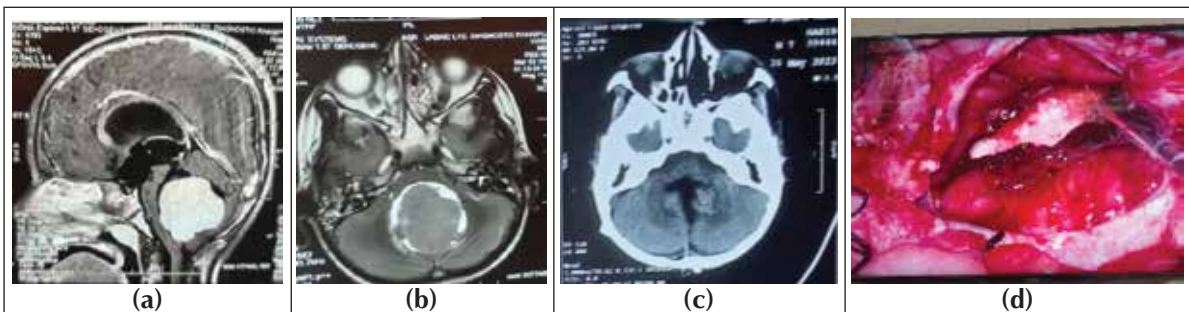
(a) Preoperative radiological image with IV contrast in a 7yrs old boy showing posterior fossa tumor (solid contrast enhancing), (b) axialT2W tumor occupying 4th ventricle, (c) postoperative CT scan showing complete removal of tumor (d) floor of fourth ventricle after complete removal of tumor.
